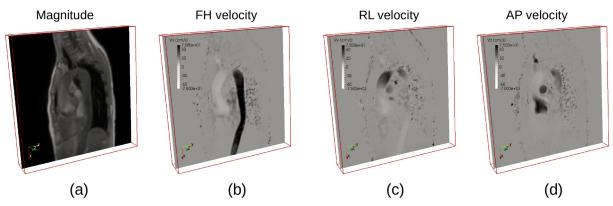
4D flow MRI acquisition of the thoracic aorta. (a) Magnitude and velocity datasets in feet-head (b) right-left (c) anterior-posterior (d) directions respectively.
